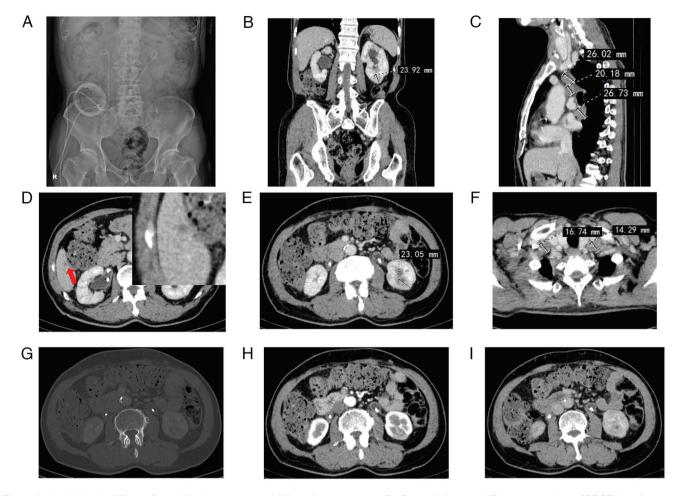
(A) Abdominal X-ray after radical cystectomy and bilateral ureterostomy. (B) Coronal plane and (E) transverse plane SPECT showing a new tumor 19x24x23 mm in size in the left kidney (the measurements shown refer to the size of the left kidney tumor). SPECT showing (C) multiple lymph node metastases in the mediastinum (the measurements shown refer to the size of the mediastinal lymph nodes), (D) a nodule measuring ~5 mm in diameter in the S6 segment of the liver (the red arrow points to the lesion) and (F) bilateral cervical lymph node metastasis (the measurements shown refer to the size of the bilateral cervical lymph nodes). (G) Bilateral renal SPECT scan. SPECT scan showing (H) bilateral renal cortical stage and (I) bilateral renal excretion period. SPECT, single-photon emission computed tomography.
